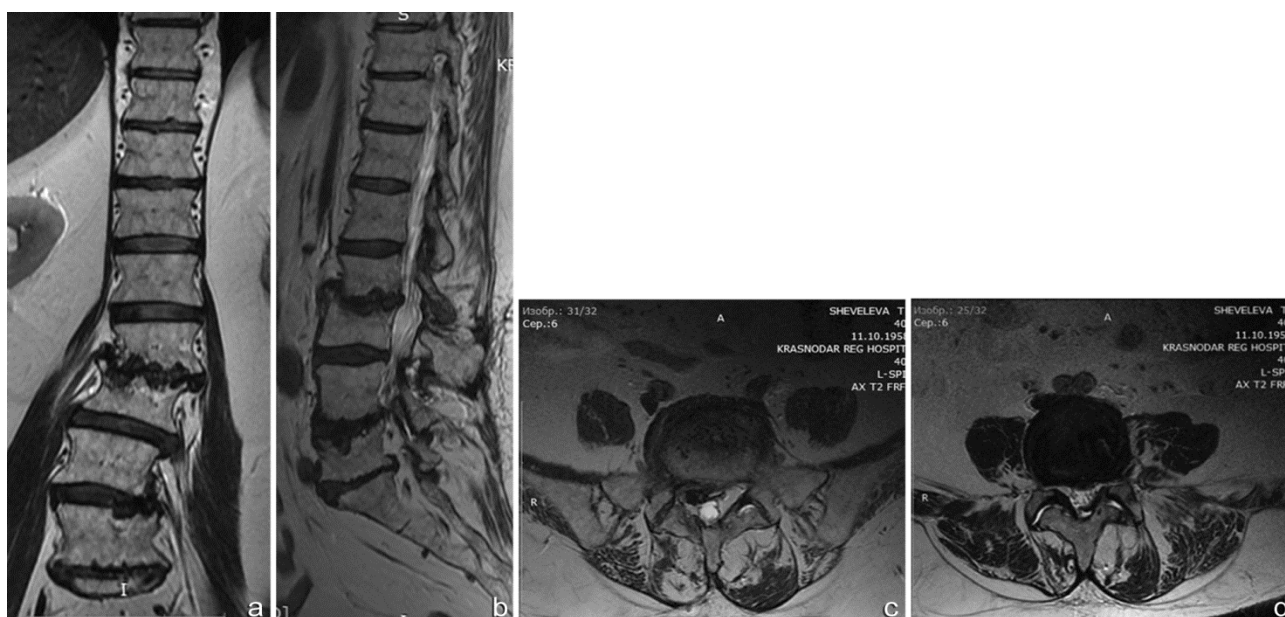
MRI scans of the spine of patient S. at primary admission to the clinic on 24.11.2014: (a) coronary projection; (b) sagittal projection; (c, d) - axial slices
